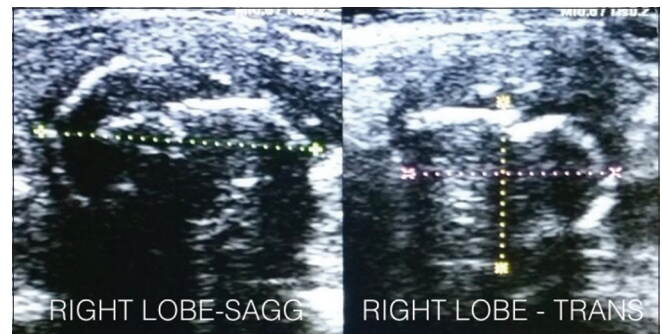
Ultrasound of neck revealed bilateral hypoechoic nodules with peripheral rim of egg-shell calcifications (left lobe nodule is shown)
